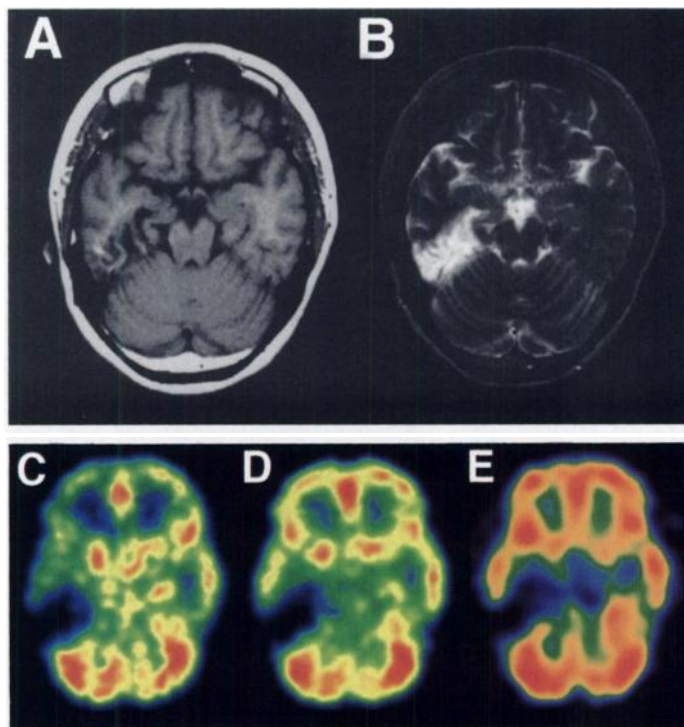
Patient 8, a 44-yr-old woman with moyamoya disease. (A) T1-weighted MR image; (B) T2-weighted MR image; (C) CBF-PET; (D) CMRO₂; (E) ¹²³I-IMZ SPECT, all obtained 35 mm above and parallel to the OM line. The posterior part of the right temporal lobe shows an infarcted area with T1- and T2-prolongation. A perfusion defect, reduced CMRO₂ and reduced uptake of ¹²³I-IMZ are observed in the lesion. The right frontal lobe is diagnosed as a lesion with misery perfusion because of the decreased CBF and preserved CMRO₂ without any abnormalities on the MR images. Iodine-123-IMZ uptake was preserved in the lesion with misery perfusion.
